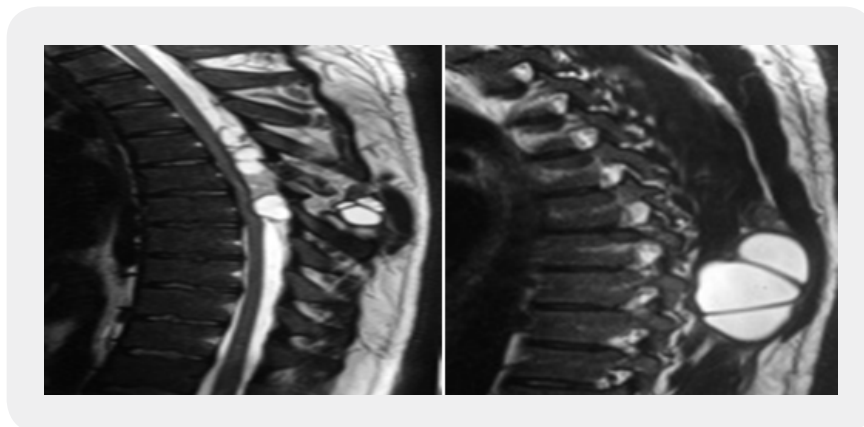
T2-weighted sagittal spine MRI: extradural, multi-vesicular cystic mass, extending from T5 to T8, and with spontaneous hypersignal
